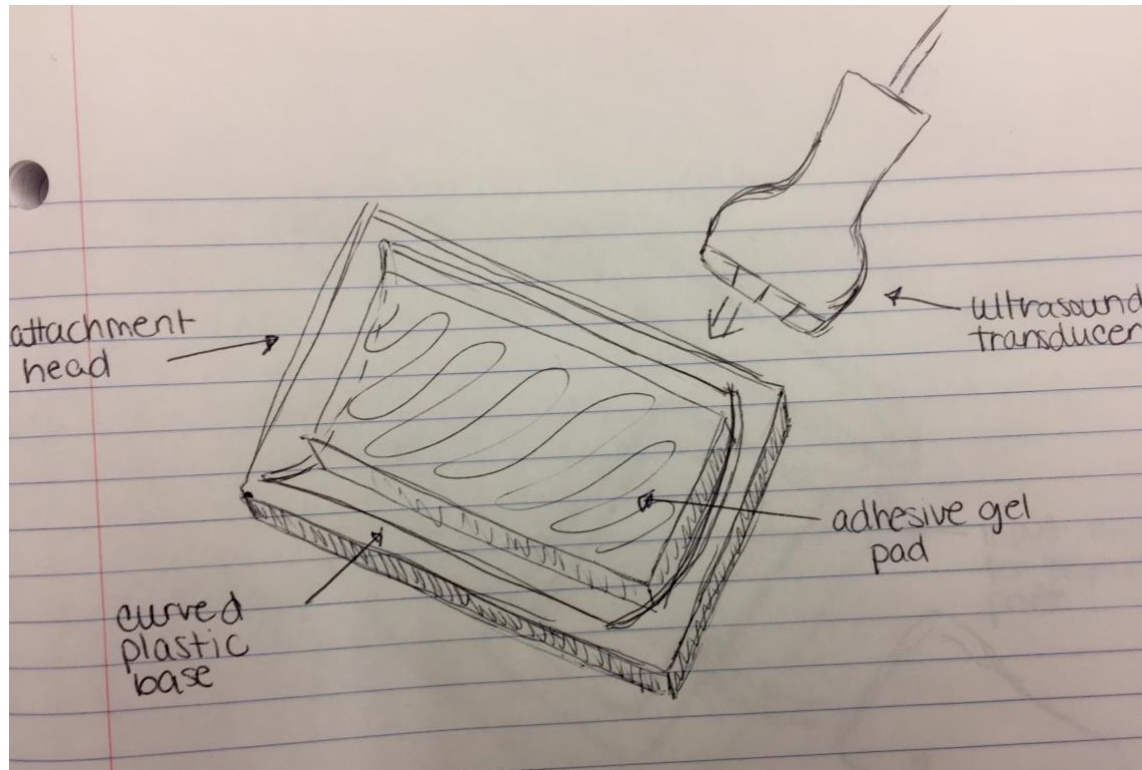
Concept 1—Description and Justification: The gel adhesive pad is placed on the patient and the transducer probe pulses to produce an image. This would work well, but the use of conductive gel will make the pad less adhesive. Also, this device will not be easily adjustable, which is a necessity in order to achieve the best ultrasound image.
